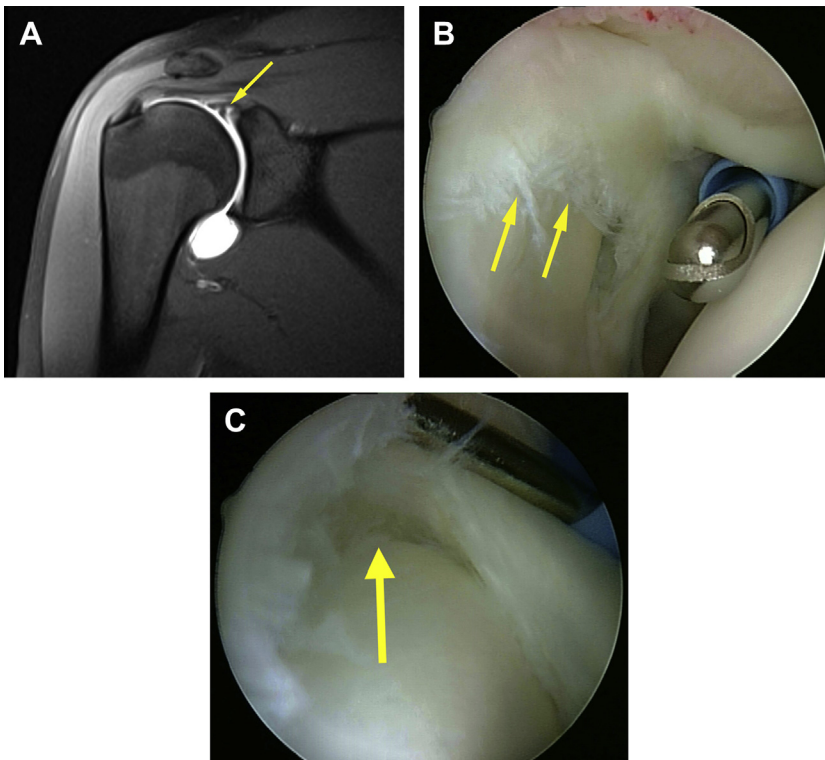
Coronal magnetic resonance image demonstrating disruption of the superior labrum in keeping with an SLAP tear (arrow, A). On arthroscopic examination, the superior labrum can be seen to be detached from its attachment to the superior glenoid (arrows, B and C).
